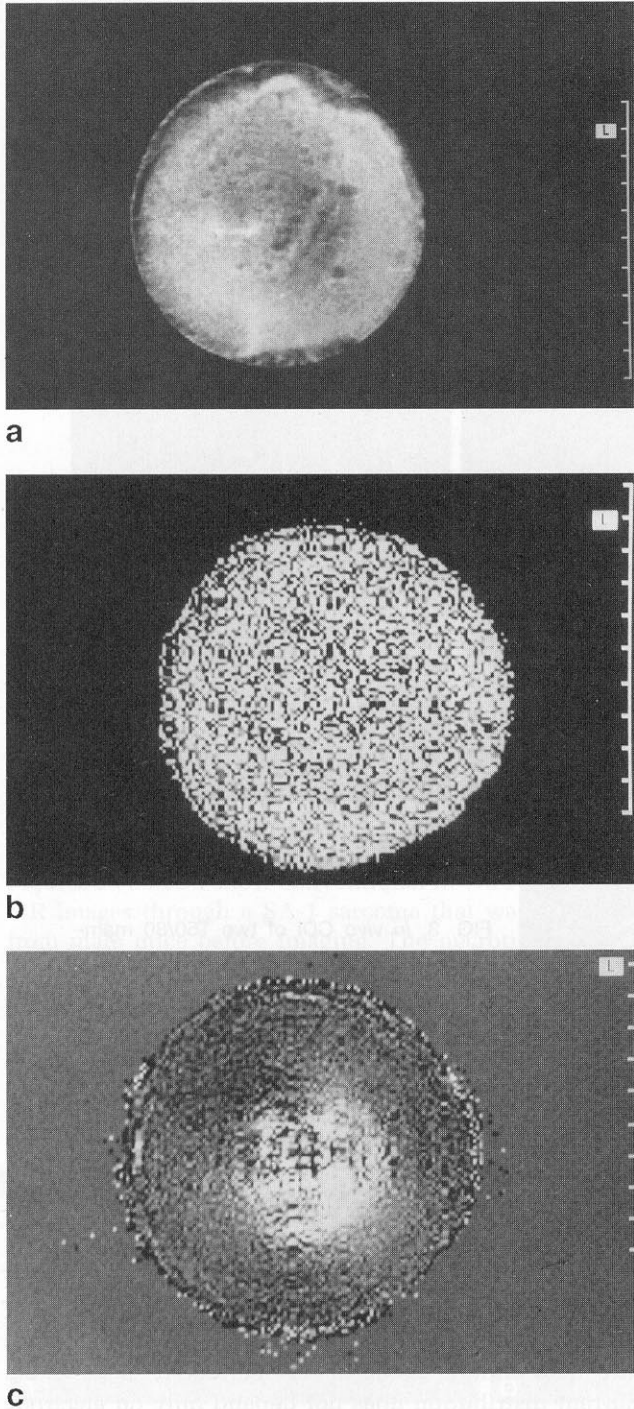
Comparison of CDI data from B-16 melanoma using flat-flat (b) and point-flat (c) electrodes ((a) represents conventional MRI, (b) CDI using flat-flat electrodes, and (c) CDI using point-flat electrodes).
